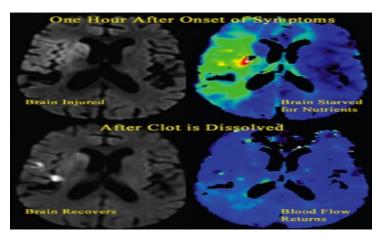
Brain MRI with VaD [88] Credit: National Institute of Neurological disorders and stroke
